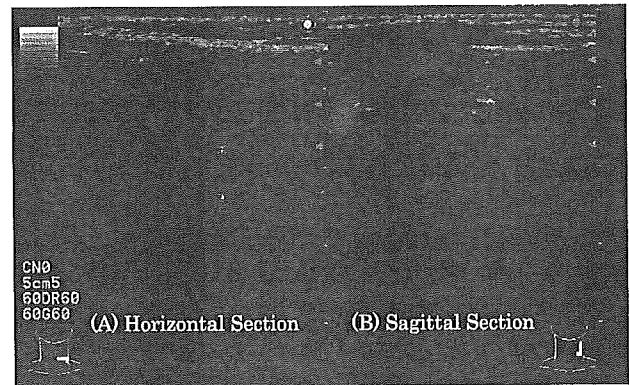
Ultrasonography of the left thyroid lobe. (A) Horizontal section. (B) Sagittal section.
